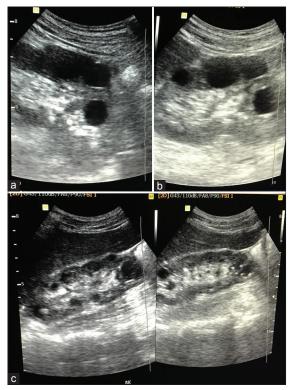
(a-c) Bilateral multiple renal cysts on ultrasonography
